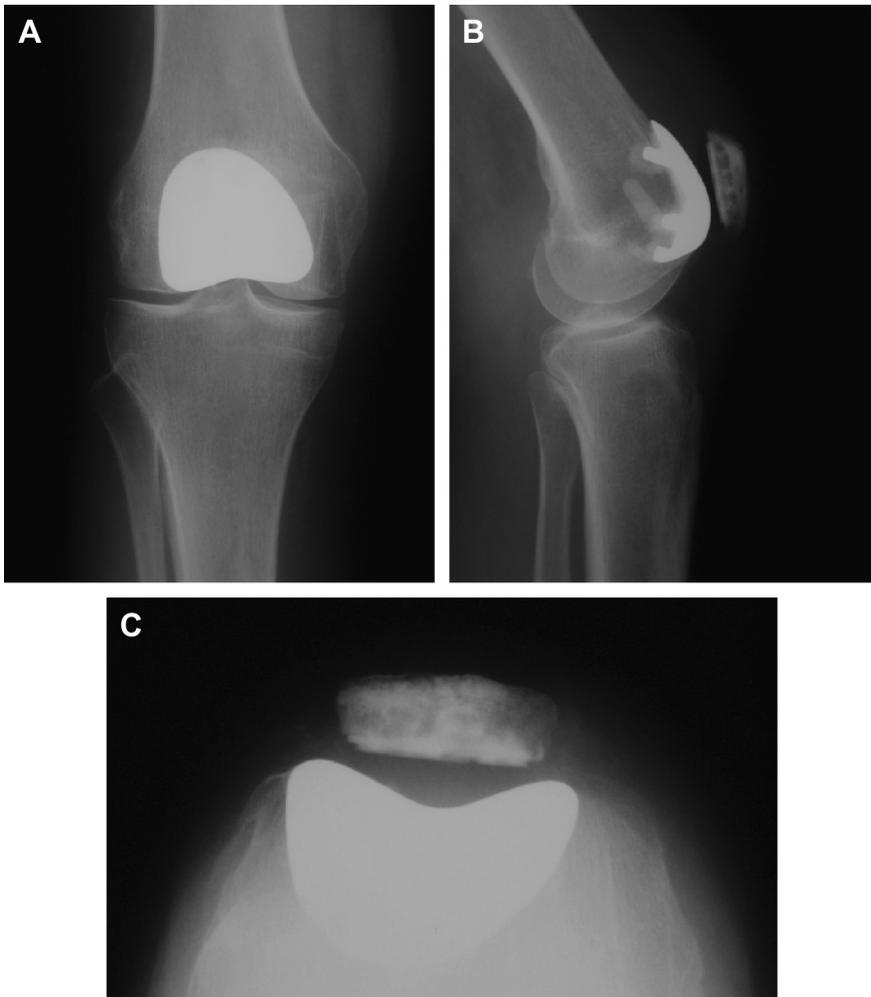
Onlay design patellofemoral arthroplasty prosthesis. Weight-bearing anteroposterior (A), lateral (B), and sunrise (C) radiographs.
